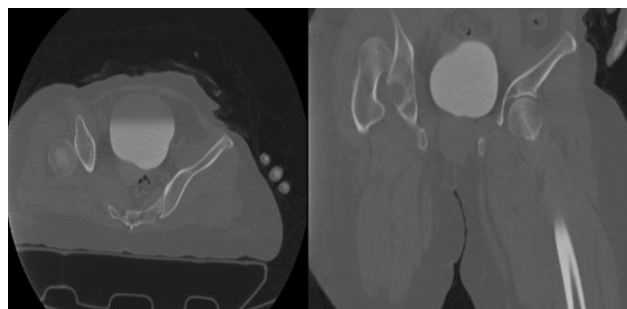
Patient's CT images after trauma
